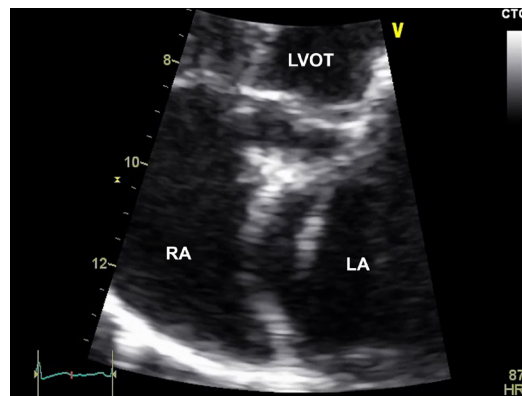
Two-dimensional transthoracic echocardiogram (apical 4-chamber view) shows 2 parallel atrial-septal structures.
